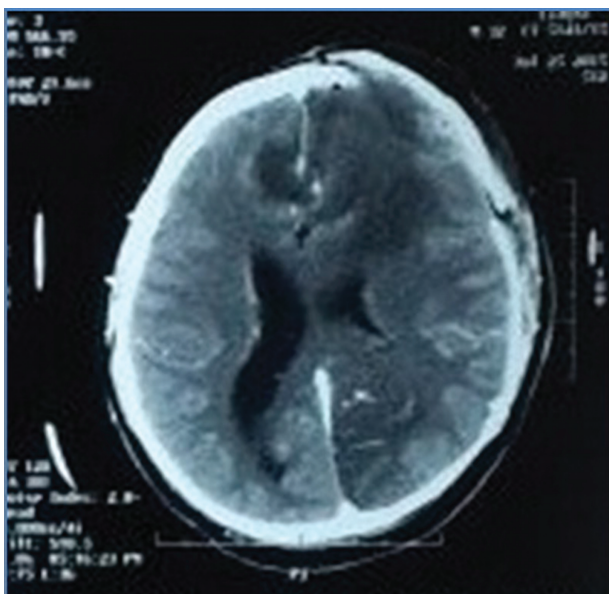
Contrast postoperative axial CT image showing residual tumor and an occipital infarct. CT, computed tomography.
